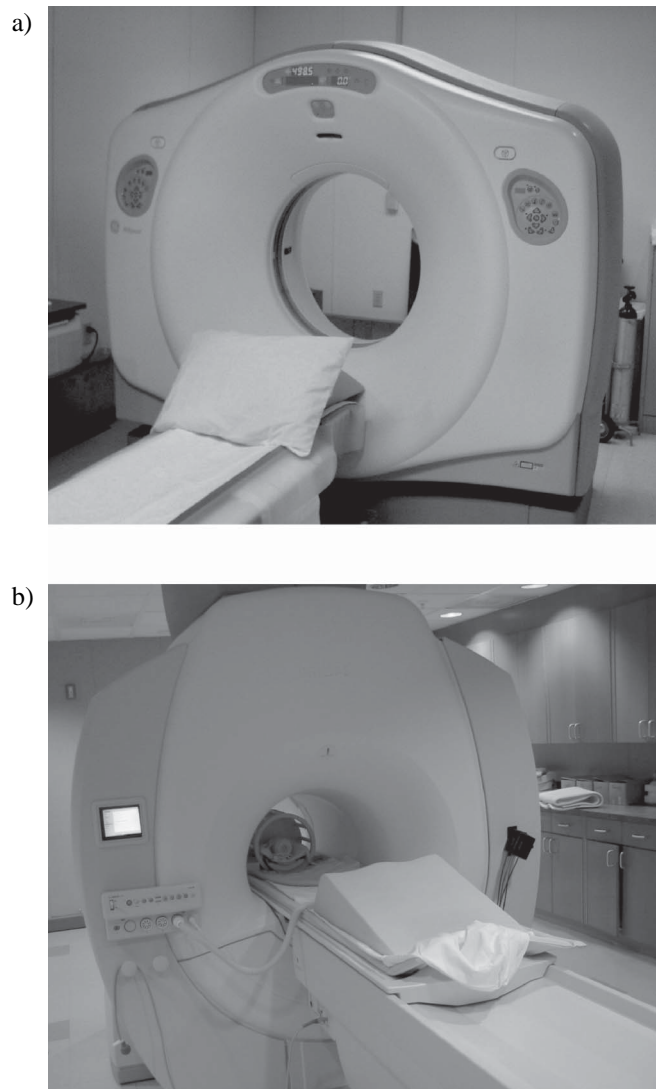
Structural Imaging Apparatus (a) CT Scanner (b) MRI Scanner.
